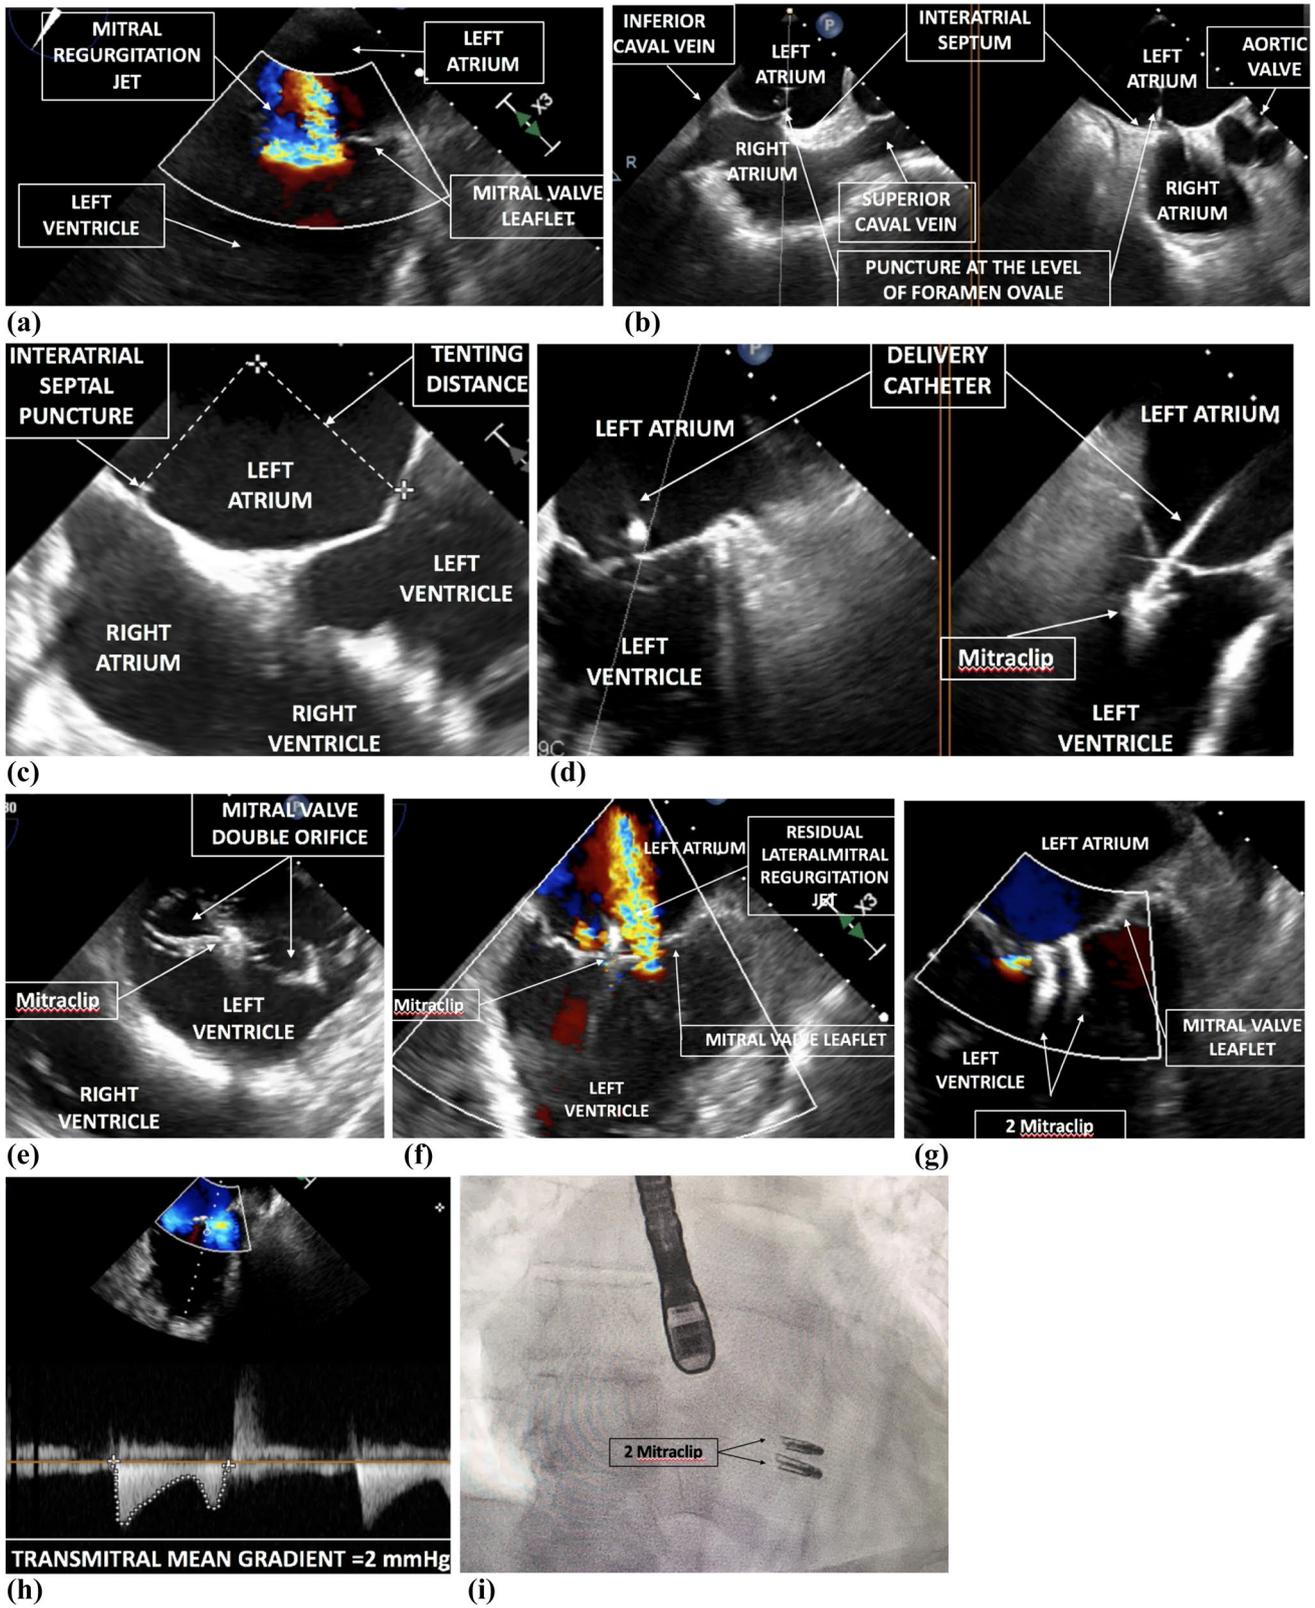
a Bicommisural view: severe regurgitant jet in a functional MR with a dysfunctional dilated ischemic LV. b Interatrial septum puncture at the level of foramen ovale. Xplane, left: bicaval view for superoinferior orientation, right: short axis view for the anteroposterior orientation. Thanks to Mullins' catheter the tenting area is appreciable. c To guarantee a proper maneuverability of the clip delivery system (in terms of movement, angulation and orientation of the catheter) it is required to measure the distance between the tenting area and the valve apparatus. d XTR MitraClip® is perpendicularly oriented to the mitral annulus, along the direction of the regurgitant jet, and then advanced in the LV through the catheter. When the device is correctly aligned, we proceed with the grasping of the leaflets. If a double orifice has been created and the echocardiography confirmed a significantly reduction in MR and a good grasping of the leaflets, the arms of the clip are closed, then blocked and at the end the clip is released. e Transgastric view: after the clip implantation on A2P2, we may observe a correct grasping of the leaflets with the creation of a double orifice. f, g After the placement of the first clip, there is still a residual lateral regurgitation. After placement of a second NTR clip more laterally there is minimal residual MR. h Mean residual transmural gradient after the clips implantation = 2 mmHg. i Fluoroscopic view of the two clips at the end of the procedure. LV left ventricle, LVOT left ventricular outflow tract
